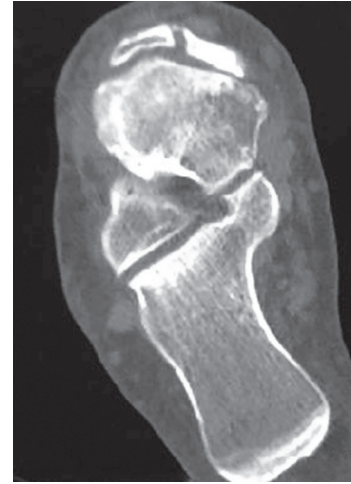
2D CT foot showing navicular non-union
